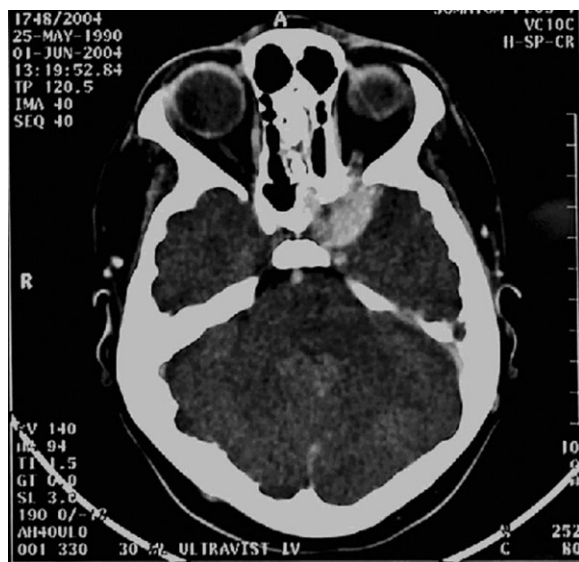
CT examination as above post contrast medium.
